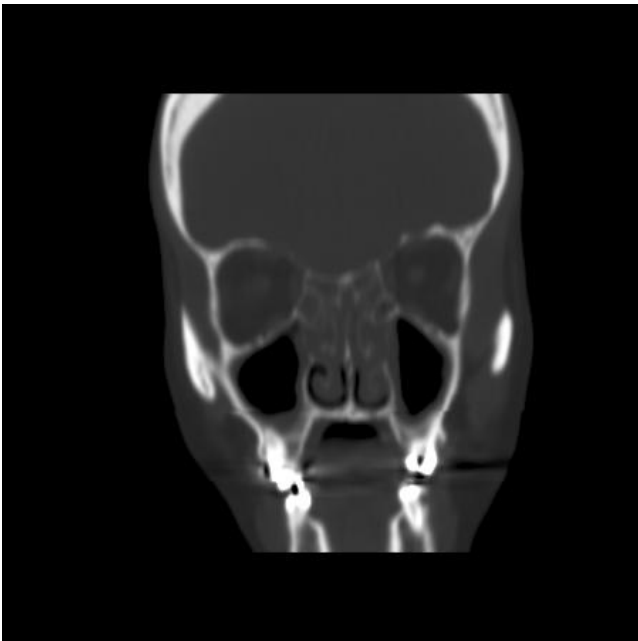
CT scan of a patient with chronic sinusitis, with blockage.
